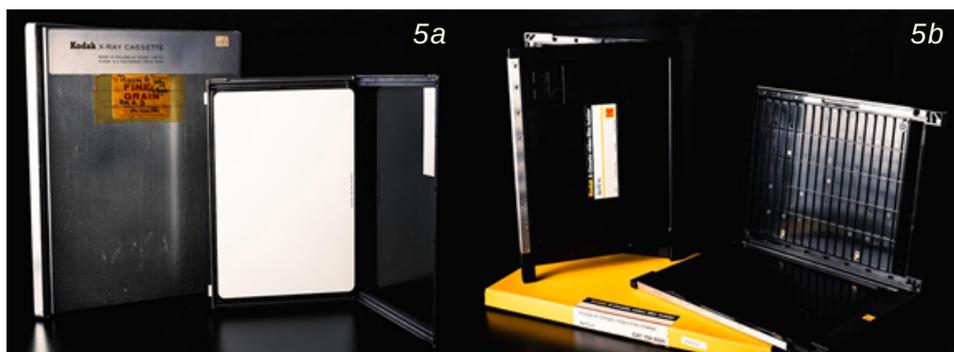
(a) Kodak film-screen X-ray Cassette with intensifying fluorescent phosphor screens where medical x-ray films taken had to be processed in a dark room. (b) Curved film-screen X-ray Cassettes were used for closed contact x-rays like mandible, or inter-condylar views of the flexed knee. Photo credit: SGH Museum
